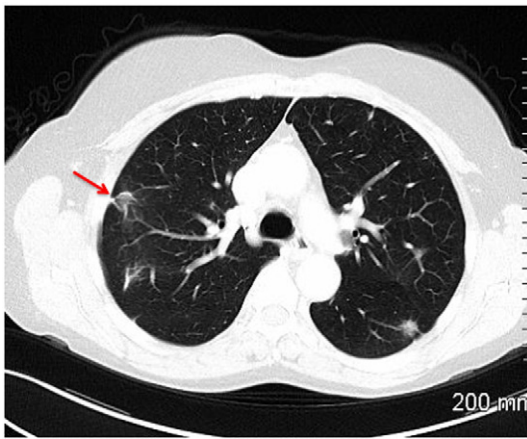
Axial CT image through the mid thorax acquired five months later demonstrates a good response to treatment. Many lesions have disappeared while others have decreased in size.
